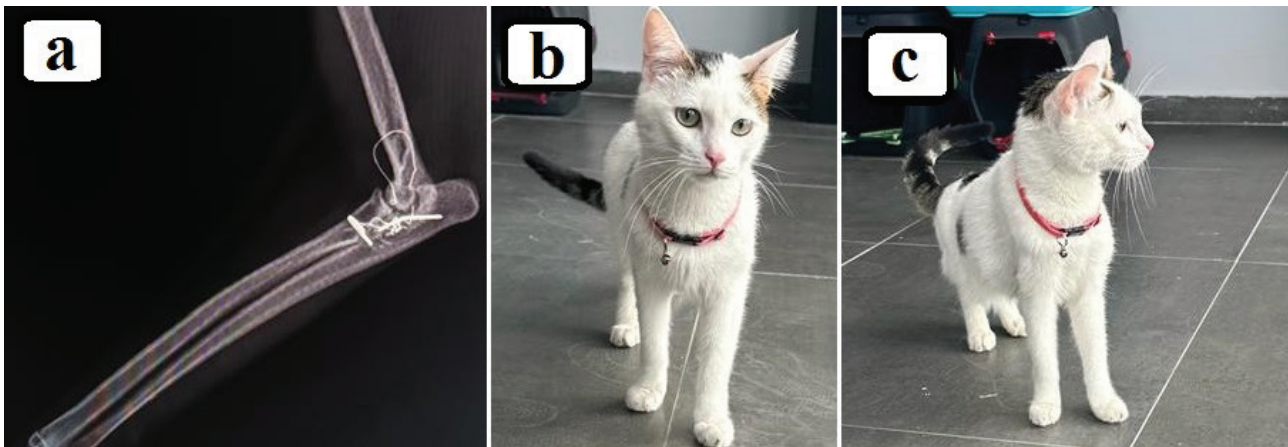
Radiography (a) and general appearance (b) of the patient on the 270th day
